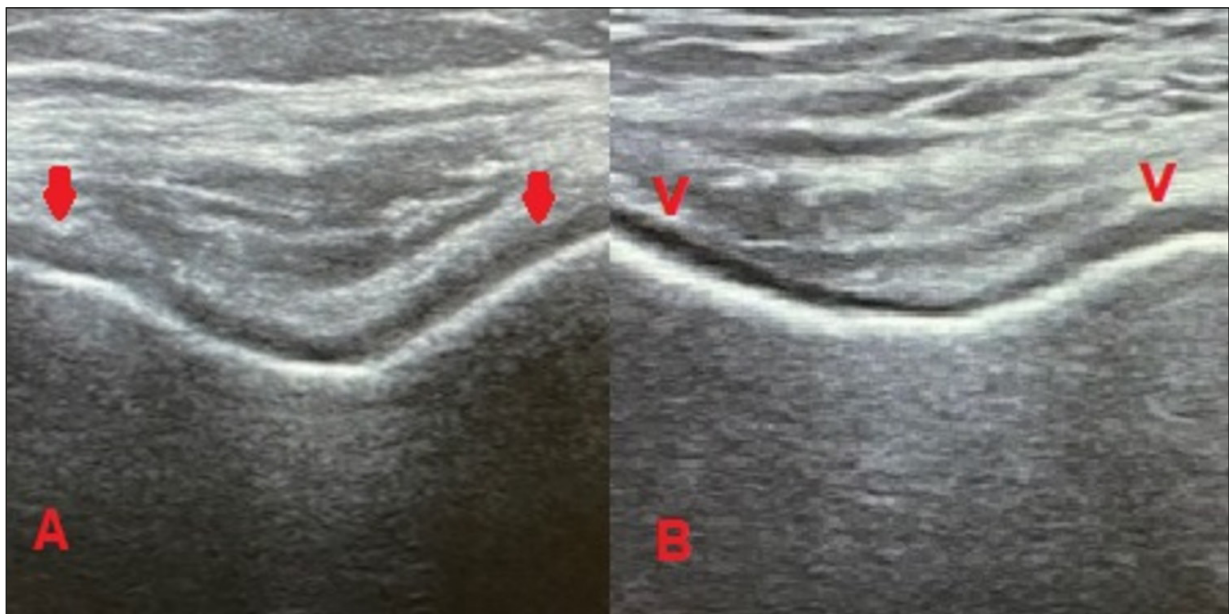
Ultrasonographic images of knee cartilage in diabetics. A, Thin cartilage with an irregular surface in a 42-year-old male diabetic (arrows). B, Thin cartilage with a smooth surface in a 47-year-old female diabetic (arrowheads).
